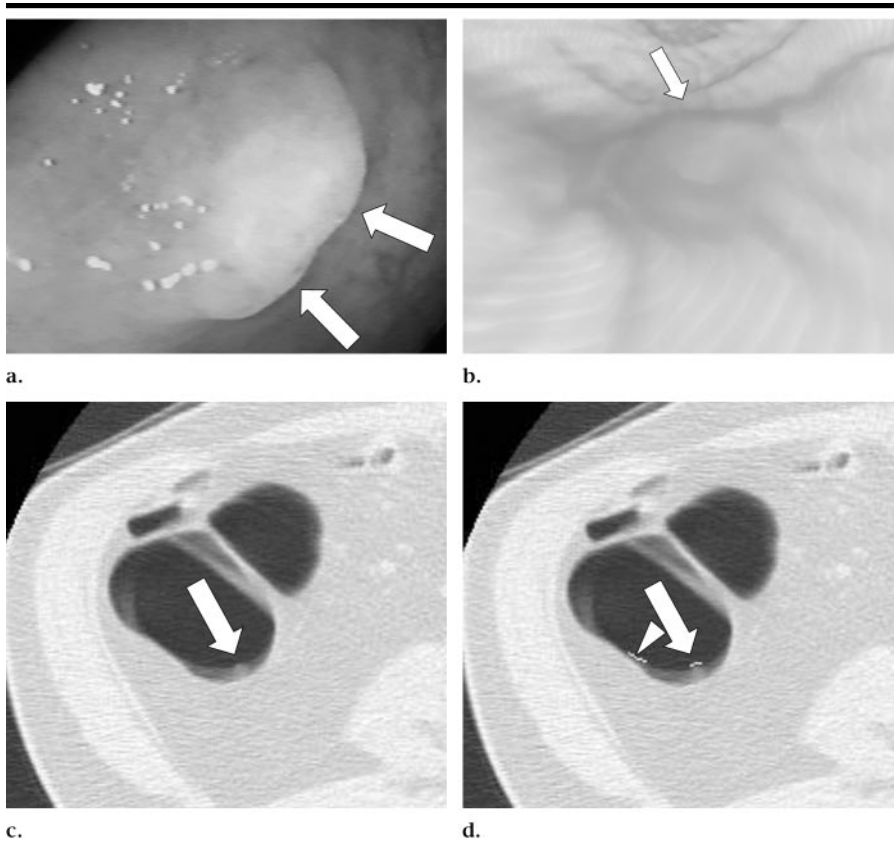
Images of a small (described as “diminutive” by the colonoscopist) tubular adenoma (arrows) that was detected in the hepatic flexure of a 66-year-old man by our CAD algorithm but not by one of two radiologists. (a) Image from conventional colonoscopy. (b) Perspective endoluminal CT colonographic image obtained with the patient in the prone position. (c) Unmarked and (d) marked transverse CT colonographic images obtained with the patient in the prone position. A false-positive detection mark (arrowhead in d) is also seen.
